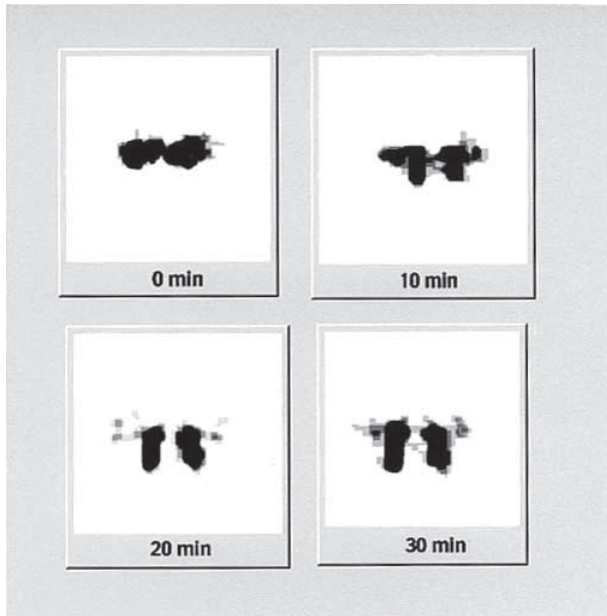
Lacrimal scintigraphy in a normal subject.
